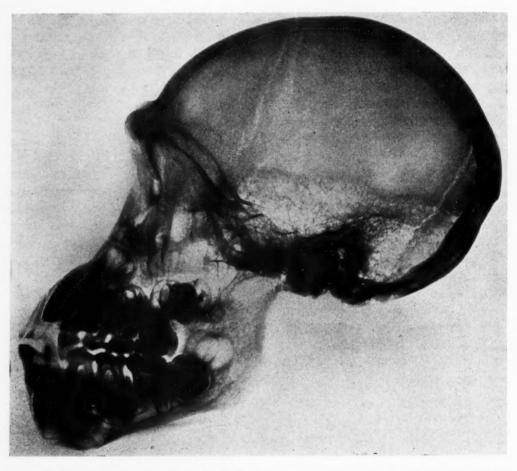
X-ray photograph of the skull of a young chimpanzee showing the second molar erupting before the second premolar, a sequence which is also followed in Neanderthal man. (Figs. 1 and 2 are from photographs by F. Melville.)
